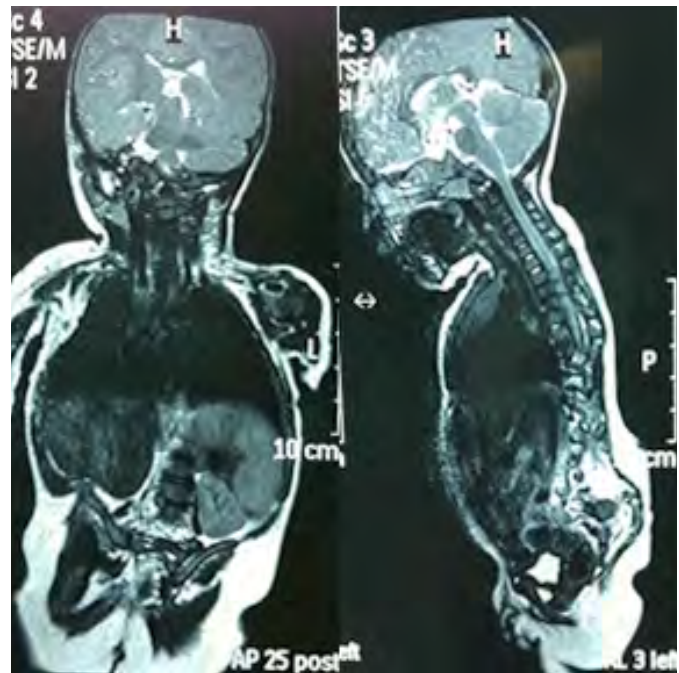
MRI image showing renal ectopia.
